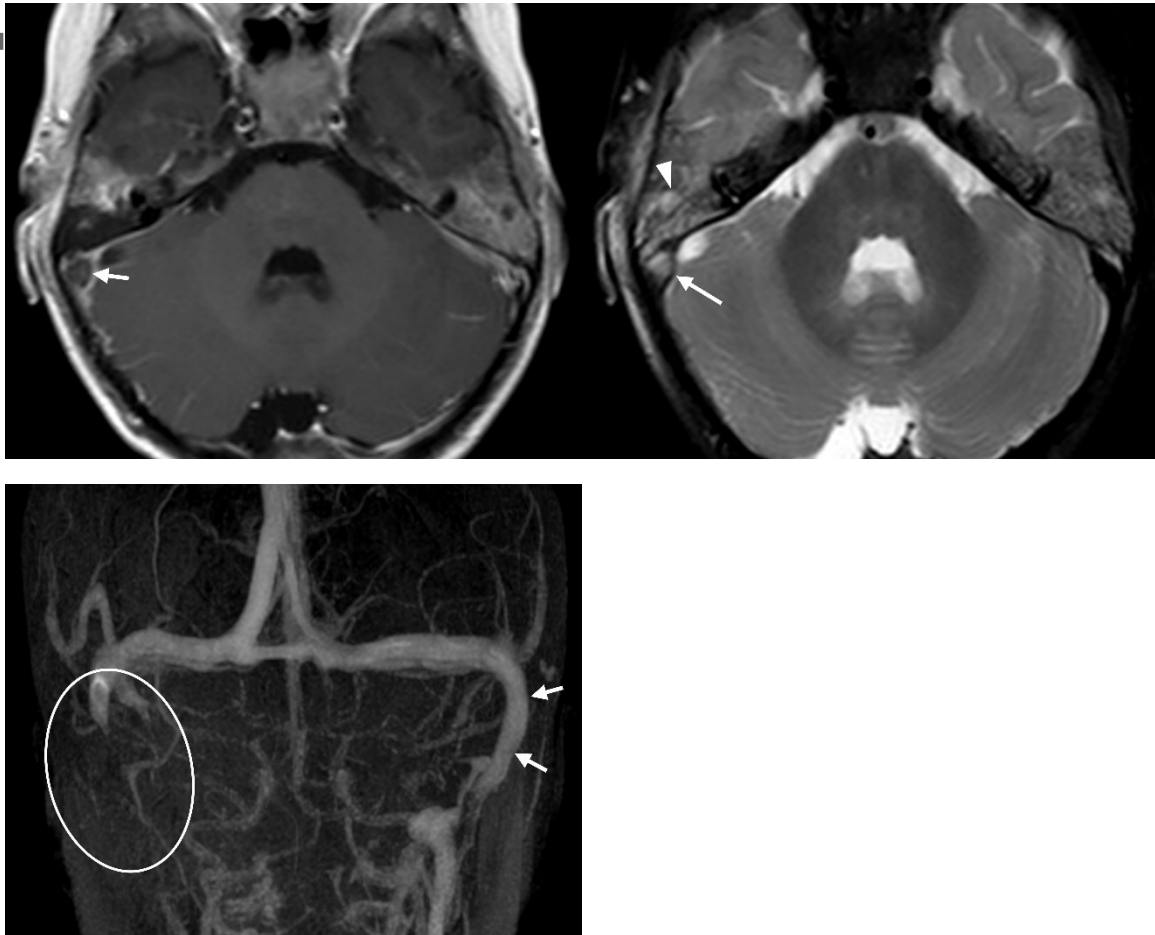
3-year-old male with sigmoid sinus thrombosis associated with coalescent mastoiditis. Fat-suppressed T2-weighted image (A) shows high signal intensity in the right mastoid (arrowhead), consistent with coalescent mastoiditis, and the right sigmoid sinus with high signal intensity (arrow), indicating the loss of the flow void. Contrast enhanced T1-weighted image (B) shows enhancement defect (arrow) in the right sigmoid sinus, and MR
